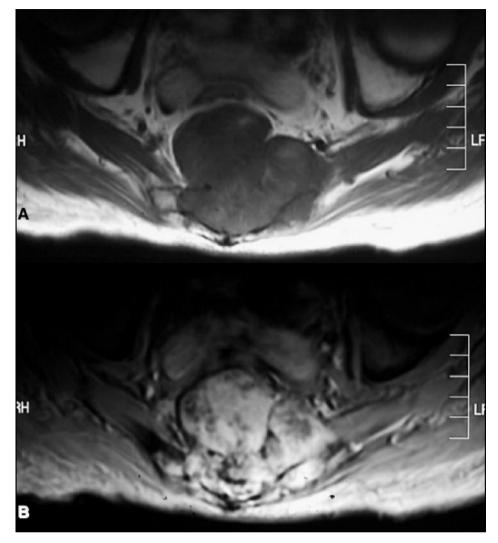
T1-weighted (A) and T2-weighted (B) MRI axial sections. The tumor can be seen to involve the sacrum and the piriformis muscles.
